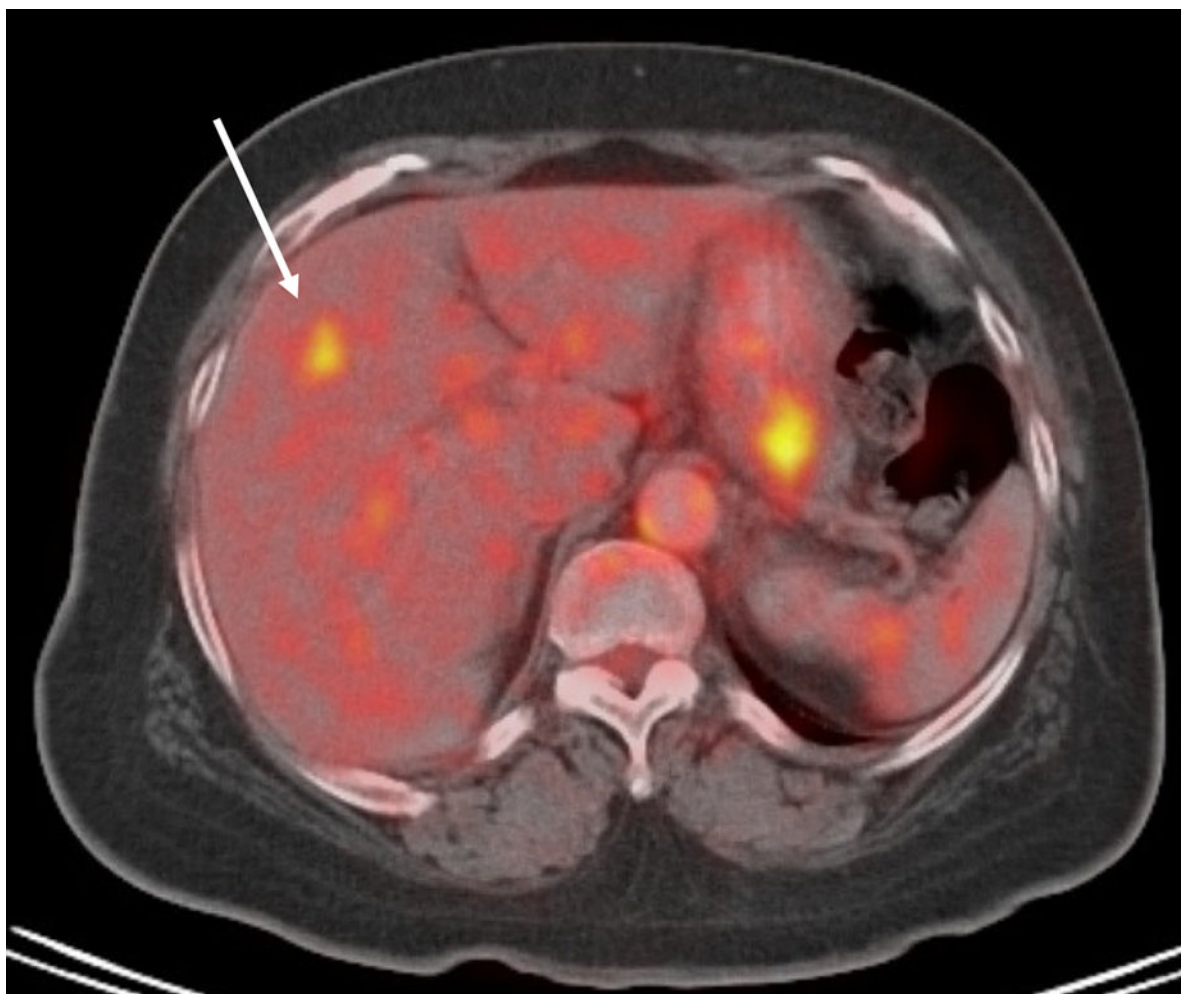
PET CT scan of the abdomen shows an increased 18-fluro-2-deoxyglucose (FDG) activity in the medial segment of the left lobe of the liver (white arrow). The brightness on the right side at the gallbladder is an artifact (as found in the presence of inflammatory conditions).
